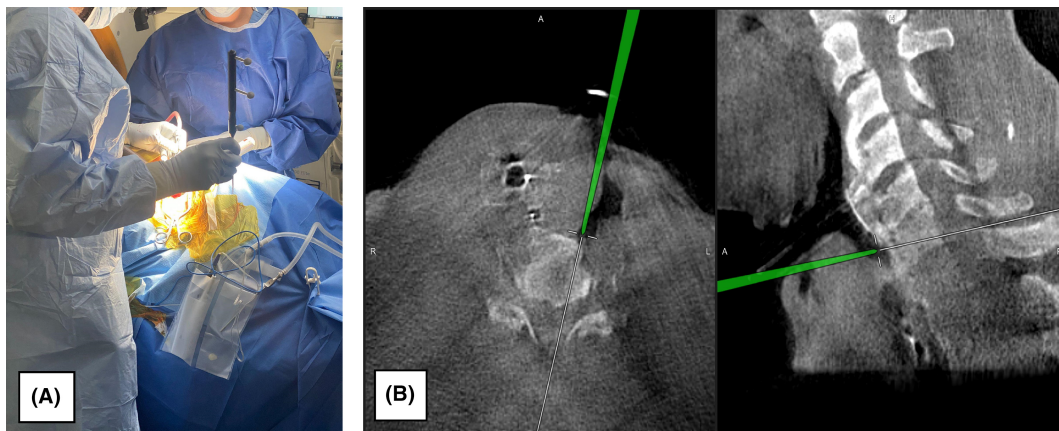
(A) CAN navigated probe (green), is a direct “line-of-sight” from the array to the navigational axial view (B) CT image from CAN software in real-time feedback of patient anatomy and trajectory seen from a lateral view on the navigation monitor.
